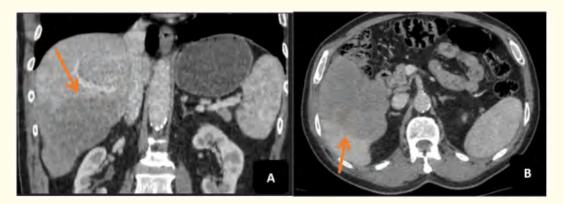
Contrast-enhanced abdominal CT scan in coronal (A) and axial (B) views (orange arrow) showing a hypodense hepatic lesion straddling segments V and VI.
